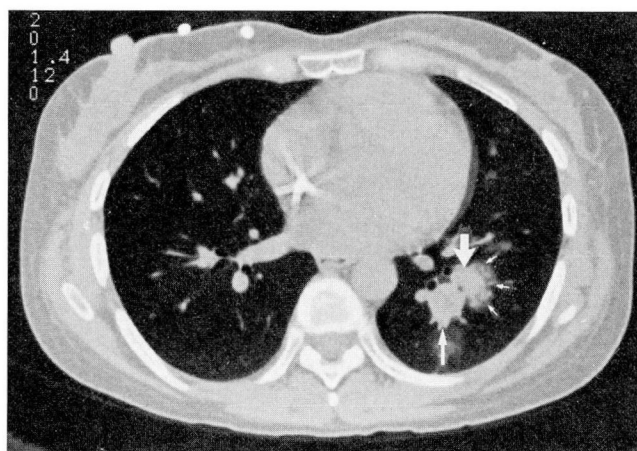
High-resolution CT scan through the lung bases reveals two soft tissue nodules in the left lower lobe (top and bottom arrows) with the newer lesion displaying a central dense nodule (top arrow) surrounded by a halo of lower attenuation (small thin arrows).
